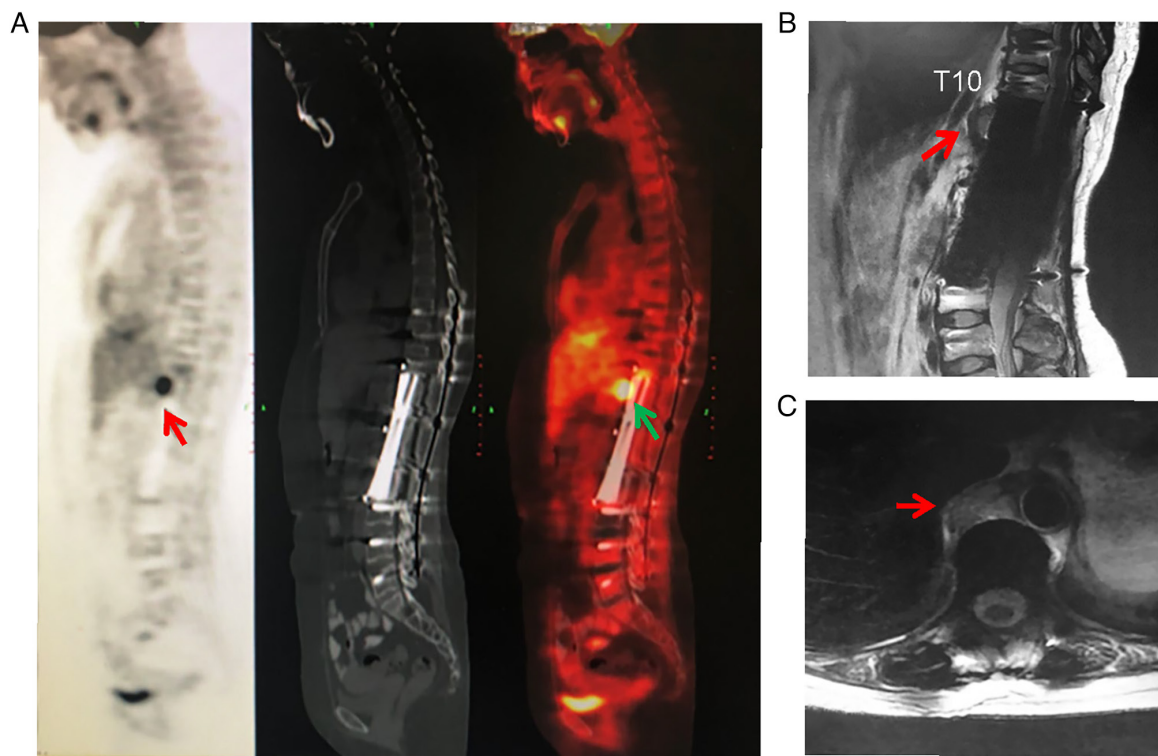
Local recurrence was detected in the right crus of the diaphragm 19 months after the index operation. (A) A new lesion was detected on PET-CT. In the left panel, the PET film is displayed, the CT film is provided in the middle panel and the right panel is the combined film. On magnetic resonance (B) sagittal reconstruction and (C) axial images, the lesion was also detected. PET, positron emission tomography.
